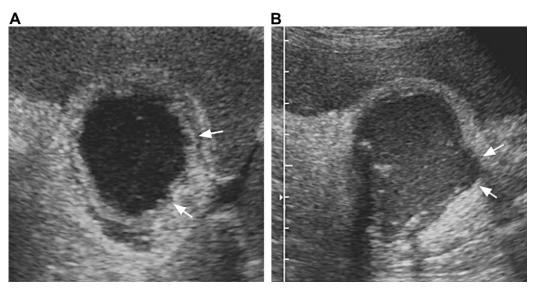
Gangrenous cholecystitis. (A) Magnified transverse view of the gallbladder shows a thick wall with several focal areas of mucosal ulceration (arrows). (B) Magnified transverse view of the gallbladder in another patient shows a focal bulge in the wall (arrows). (Data from Middleton W, Kurtz A. Ultrasound: the requisites. 2nd edition. Philadelphia: Mosby; 2004. p. 38.)
